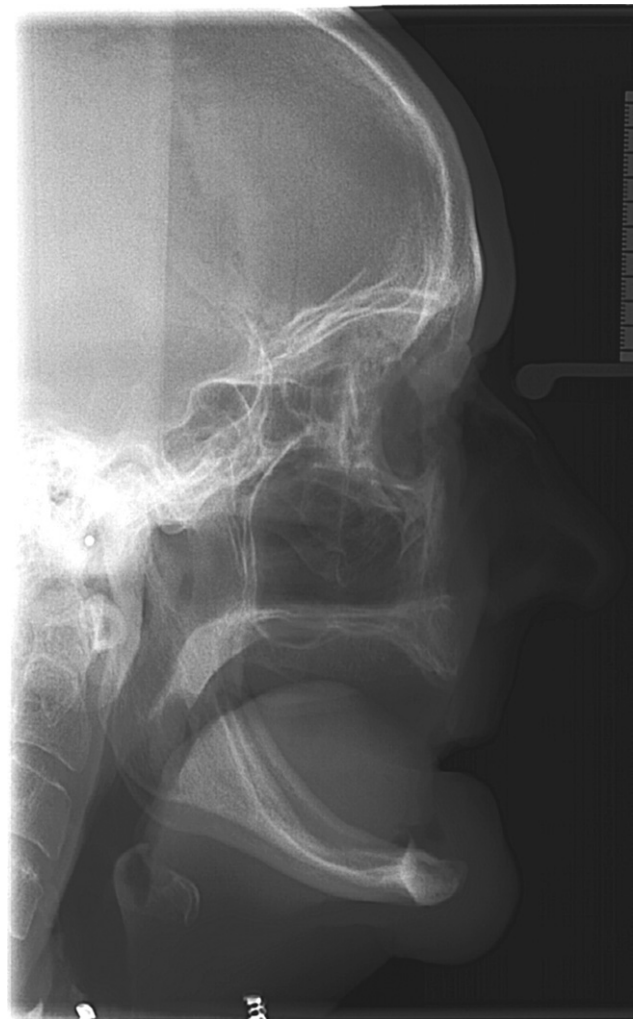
Baseline lateral cephalometric radiograph of the same patient as in Figure 1.
